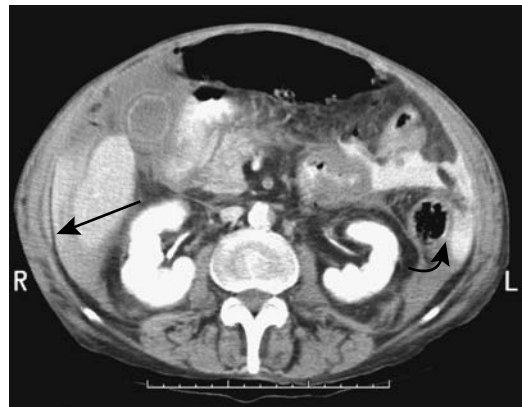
Acute abdomen secondary to jejunal perforation. Oral and intravenous (IV) contrast-enhanced CT reveals ascites and pneumoperitoneum. Higher density material is present within this fluid adjacent the liver (arrow) and also in the left upper quadrant (curved arrow). Although angiography revealed patent vessels, surgery suggested emboli and ischemia for the patient's perforation. (Courtesy of Patrick Fultz, M.D., University of Rochester.)
